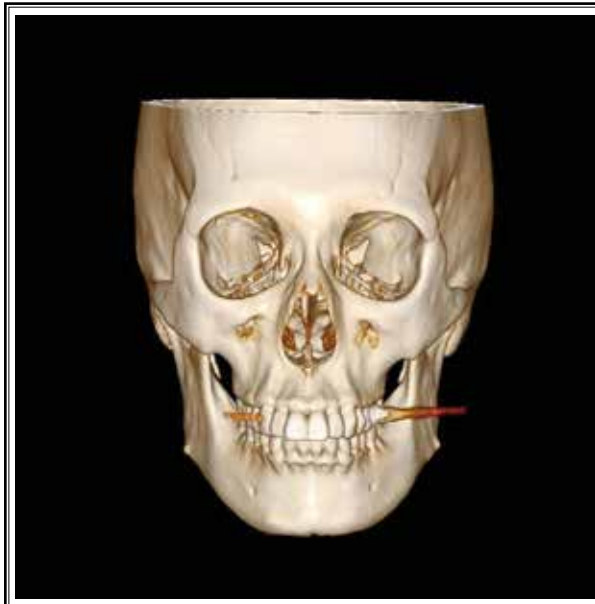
Facial bone 3D CT image showing absence of supraorbital notch or foramen.
